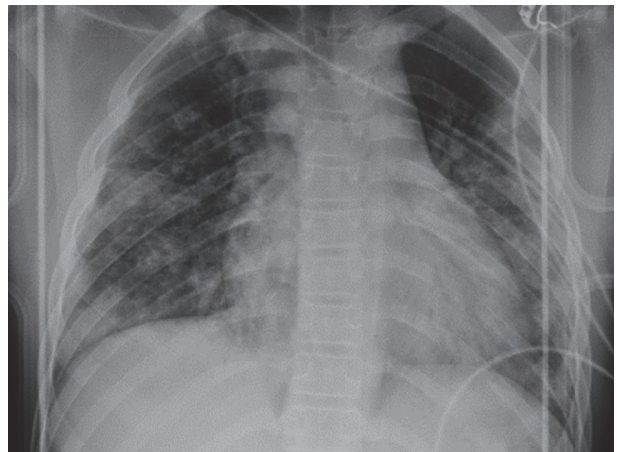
Chest radiography on admission.
